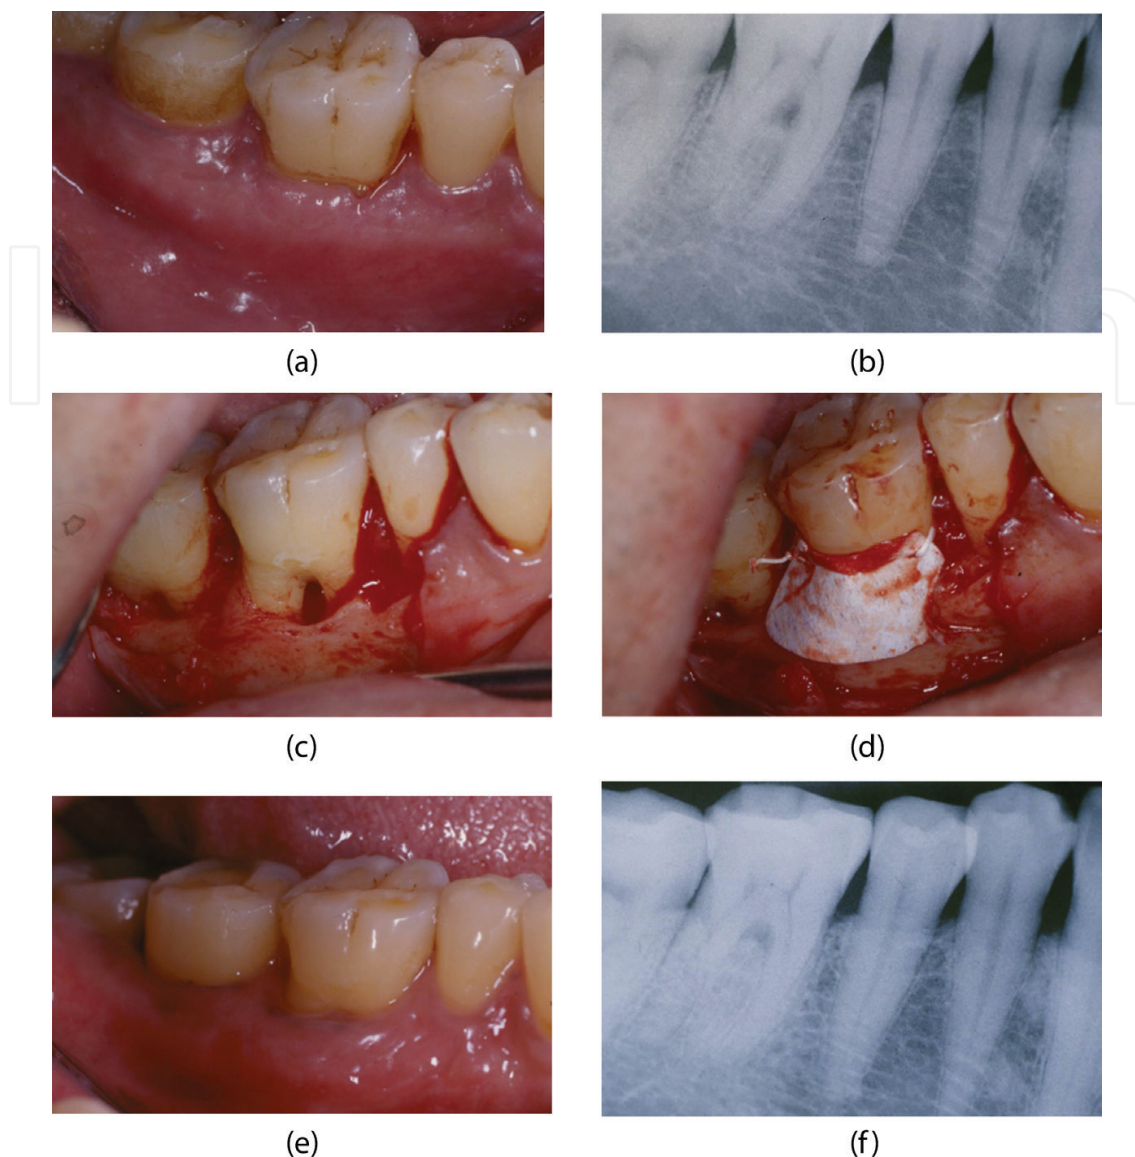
Clinical results of guided tissue regeneration using bone graft and membrane. (A) Preoperative view. (B) Preoperative periapical radiograph. (C) Buccal view after elevation of a full thickness flap showing involvement of the furcation at the mandibular right first molar. (D) The defect area was filled with bone graft and resorbable membrane. (E) The clinical photograph of the mandibular right first molar. (F) The radiograph of the mandibular right first molar with regeneration of the furcation area.
